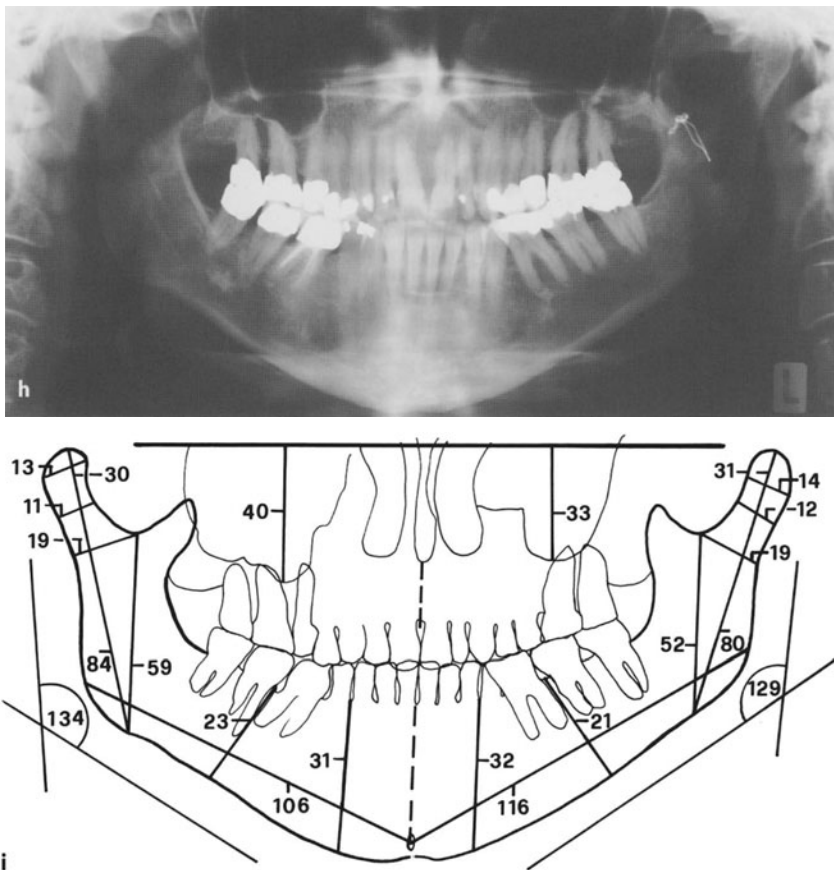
Unilateral H.E., slender type, before puberty. h The panoramic view taken 42 years after the unilateral sagittal splitting of the left ramus still permits the diagnosis of a former H.E. of the left side. i The tracing of that late panorama radiograph still proves the clear elongation of the left horizontal ramus
